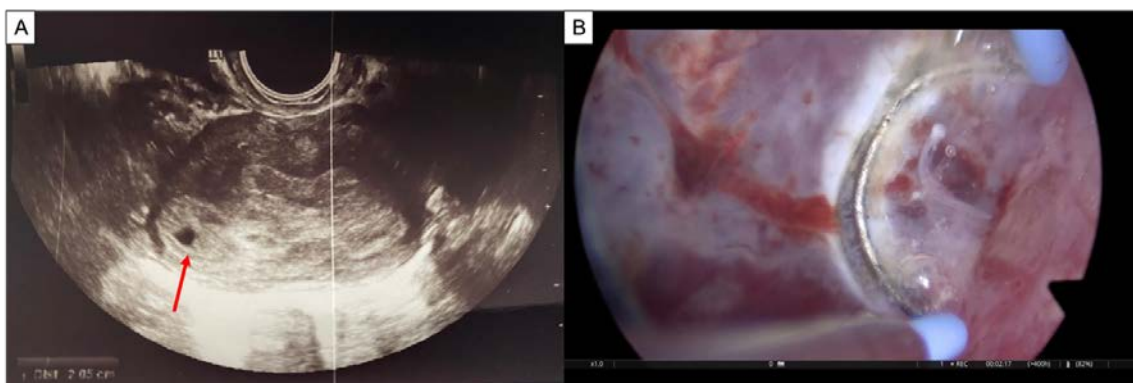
A) Ultrasonographic feature from Case I: a gestational sac of 20 mm (red arrow) in the right uterine *cornua* with the interstitial sign; B) View of the gestational sac at the moment of hysteroscopic resection.
